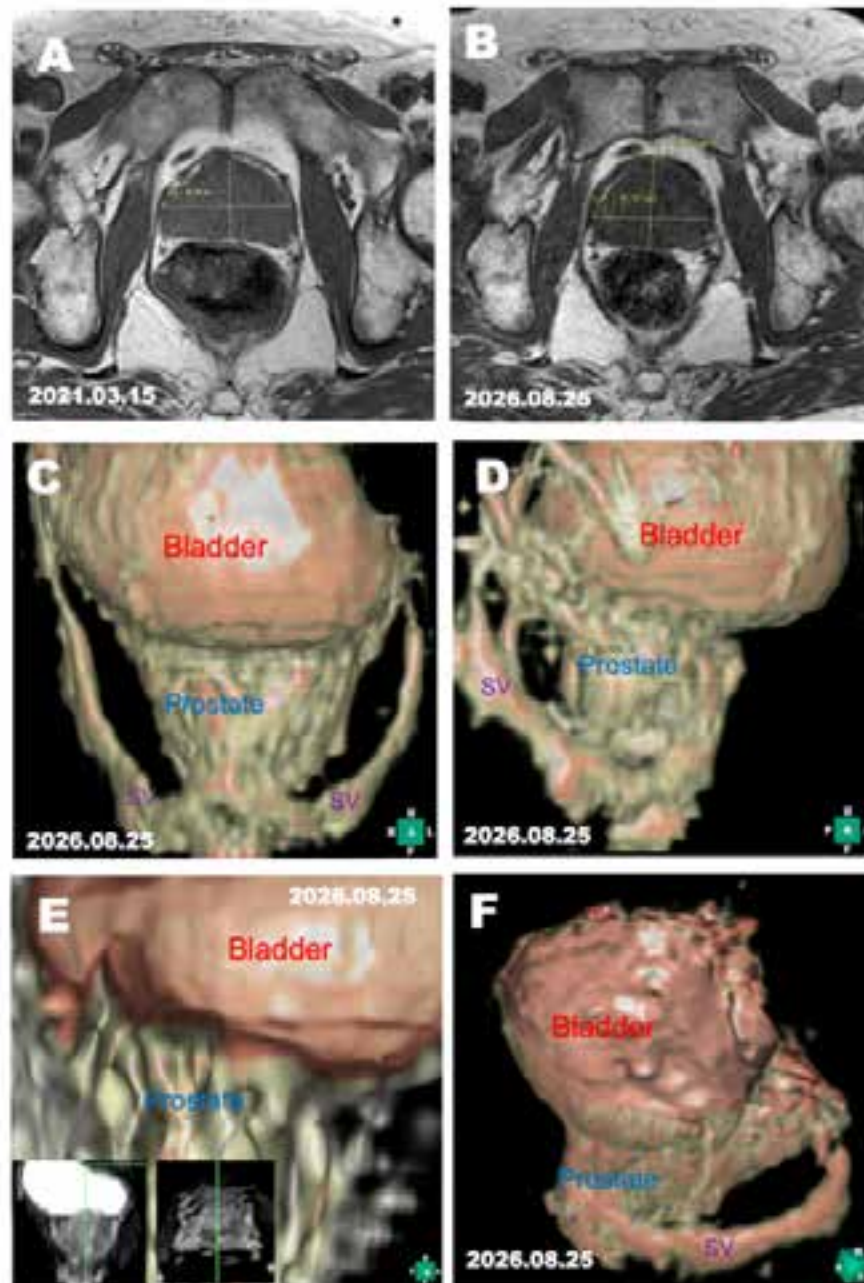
MRI images before and after cytokine-based anti-oncogenic treatment. Panels A and B show prostate MRI images obtained on March 15, 2021, and August 25, 2026, respectively. Panels C–F show 3D MRI images obtained on August 25, 2026: an anterior view (C), a right lateral view (D), a central cutting-section image (E), and a 3D image showing the bladder mucosa viewed from the upper-left oblique direction (F).
